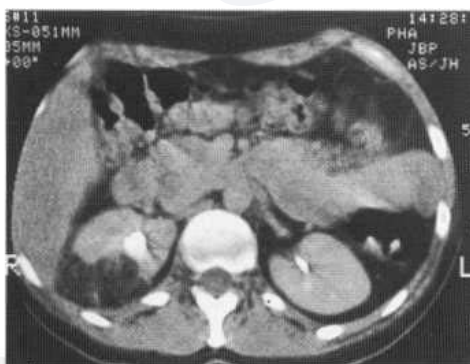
CT showing predominantly fat-density solitary angiomyolipoma (A) and multiple purely fat-density bilateral angiomyolipomas (B) in tuberous sclerosis. The latter case has presented with a left-sided perinephric haemorrhage seen as a soft-tissue rim around the kidney but delineated externally by the perinephric fascia.
